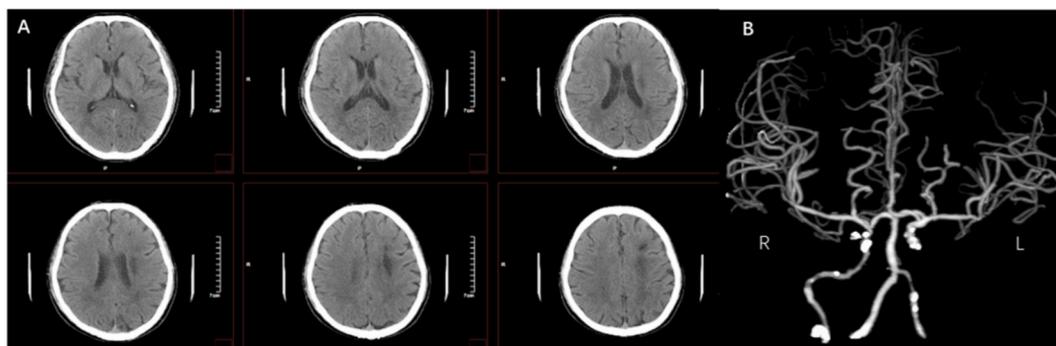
The computed tomography (CT) and cerebral computer tomography angiography (CTA) of the patient. (A) Non-contrast CT showed no signs of bleeding or massive cerebral infarction; (B) Cerebral CTA showed occlusion of the left internal carotid artery.
